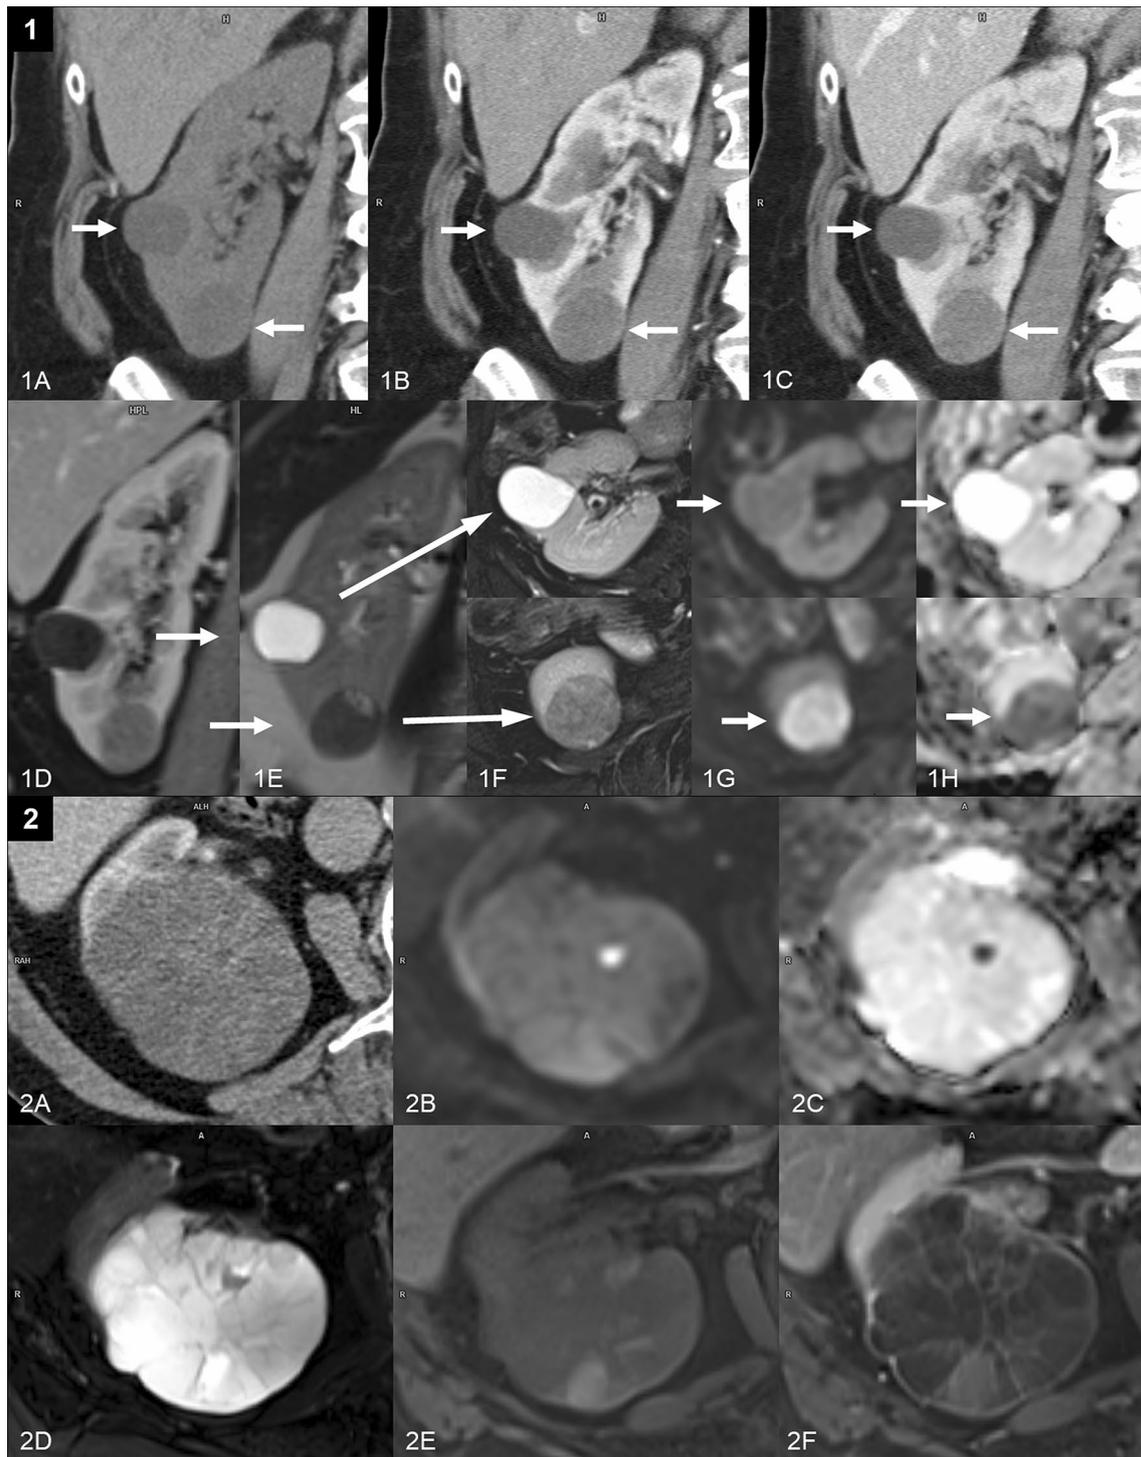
1 The picture shows two cystic lesions in the same kidney—the upper arrow line shows renal cyst classified according to CT as Bosniak I (homogenous signal of water with free diffusion), the lower arrow shows the lesion originally described as cyst Bosniak IIF based on CT, after MRI examination Bosniak IIF lesion was reclassified as PRCC (different signal characteristics, non-homogenous structure, restricted diffusion). Noncontrast CT (1A), CT after iv. contrast administration in arterial (1B) and venous phase (1C). MR imaging in contrast-enhanced T1 fat suppressed (1D), T2 (1E), T2
